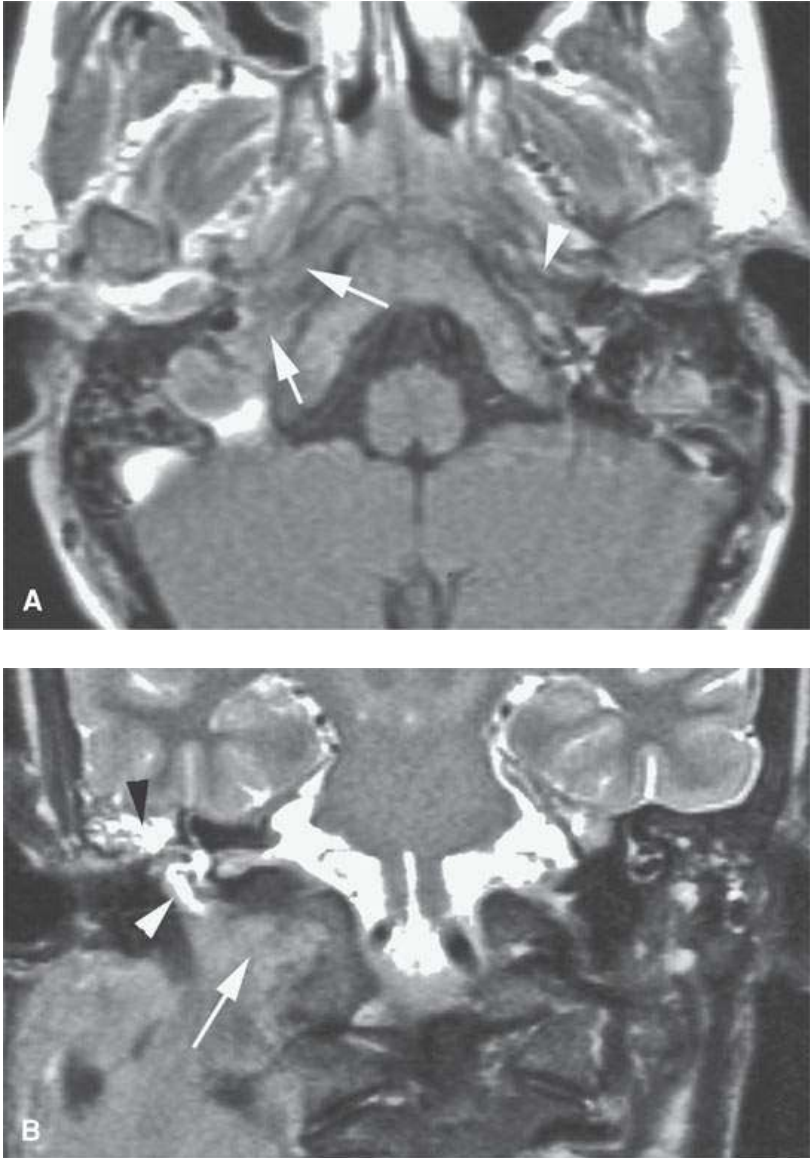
Magnetic resonance imaging of a patient with non-Hodgkin lymphoma of the petrous apex. A: Contrast-enhanced T1-weighted image showing minimally enhancing lymphoma infiltrating the petrous apex and mastoid portions of the temporal bone including the jugular fossa (*arrows*) compared to the normal side (*arrowhead*). B: T2-weighted coronal image showing the lymphoma to be about isointense to gray matter and causing eustachian tube obstruction with tumor extending into the middle ear (*white arrowhead*) and fluid and/or mucosal thickening in the middle ear and mastoid (*black arrowhead*).
